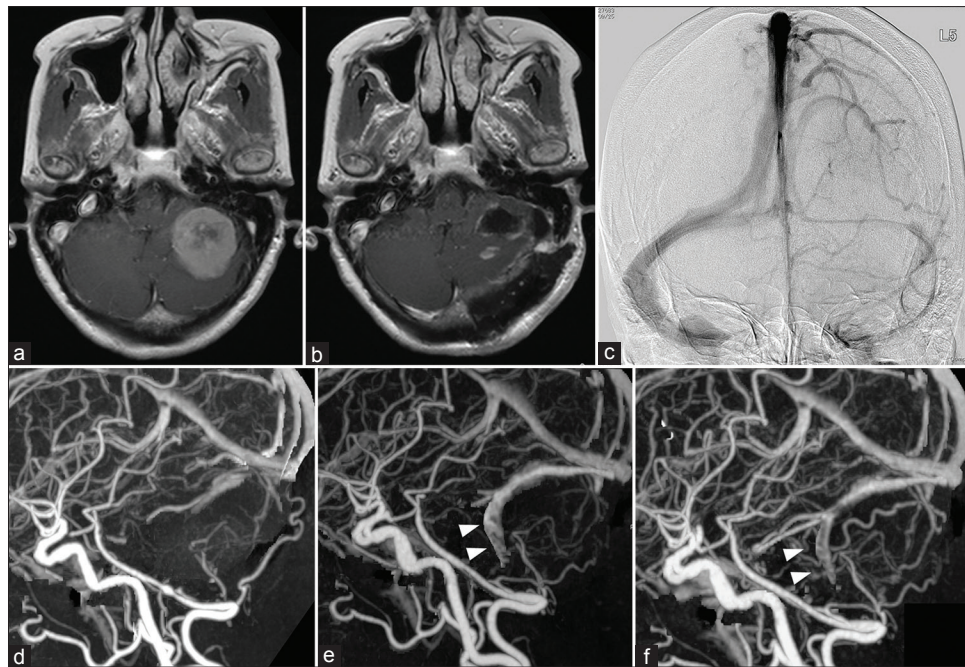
Surgical resection of a left cerebellar brain tumor in a 53-year-old female. Resection of the left cerebellar brain tumor (a) proceeded via the lateral suboccipital approach (b). Preoperative digital subtraction angiography shows hypoplastic left, compared with the right transverse sinus (c). Preoperative three-dimensional-computed tomography angiography shows no abnormalities (d). Slight cerebral venous reflux evident on a three-dimensional-computed tomography angiography image at 6 months after surgery (e; arrowhead) became symptomatic (left retro-auricular bruit) at 16 months after surgery (f; arrowhead)
